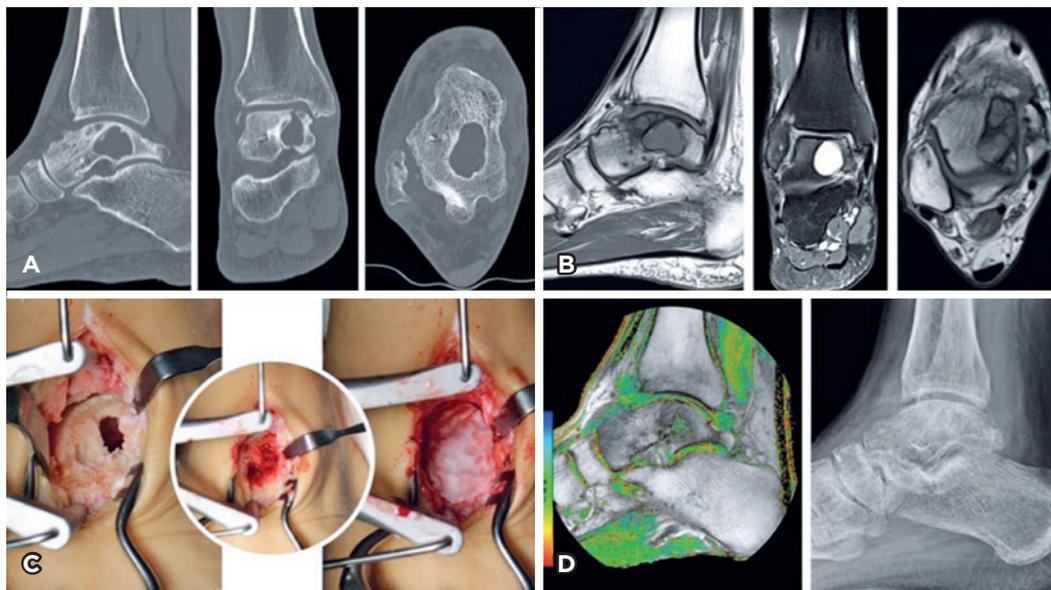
Autologous matrix-induced chondrogenesis (open) in severe osteochondral lesions of the talus with giant cysts: A. Computed tomography images (Sag, Cor, Trans); B. Images (SagT1, CorT2, TransT1); C. Through an anteromedial longitudinal incision and with a pin distractor, the area of the lesion is exposed and the “entrance” of the cystic lesion identified; The lesion is curetted and cleaned, being filled with an autologous cancellous bone graft and then covered with a chondroinductive membrane that is fixed to the bed with fibrin glue; D. T2 map (sagittal) and plain radiograph of the ankle (lateral) showing integration of the membrane into the bed; note the recovery of the tibiotalar joint space on the lateral radiograph.
